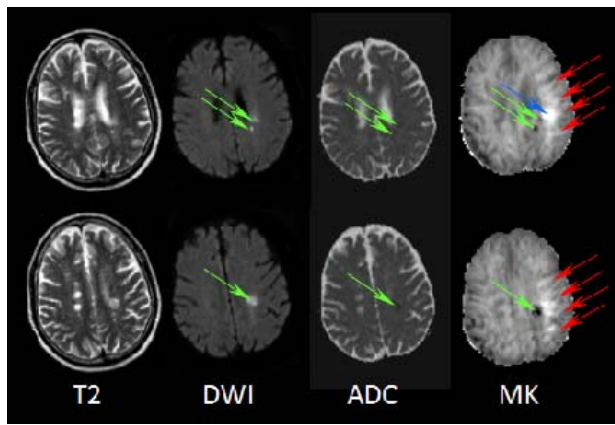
T₂, DWI, ADC and MK maps from two adjacent slices from a 75 y/o male presenting with R-sided weakness. Multiple foci of predominantly left deep WM acute infarction are seen with DWI hyperintensity, ADC decrease and MK decrease (green arrows). The MK map shows additional foci of very high MK (blue arrow, mean MK = 1.84 ± 0.16) surrounded by a region of diffusely increased MK (red arrows, mean MK = 1.23 ± 0.23) within the subcortical white matter of the left parietal lobe located lateral to the region of acute infarct. This region is not identified in the ADC or DWI images.
